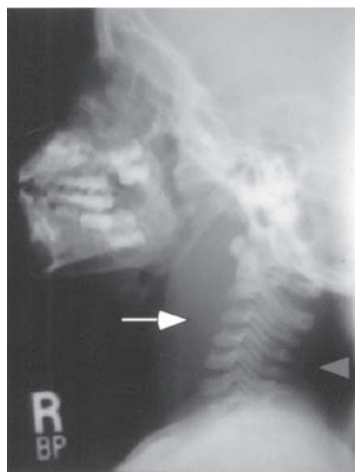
Lateral radiograph of the soft tissue of the neck. Note the large amount of prevertebral edema (solid arrow) and the collection of air (dashed arrow). Findings are consistent with retropharyngeal abscess. (Used with permission from Dr. Gregory J. Schears.)
